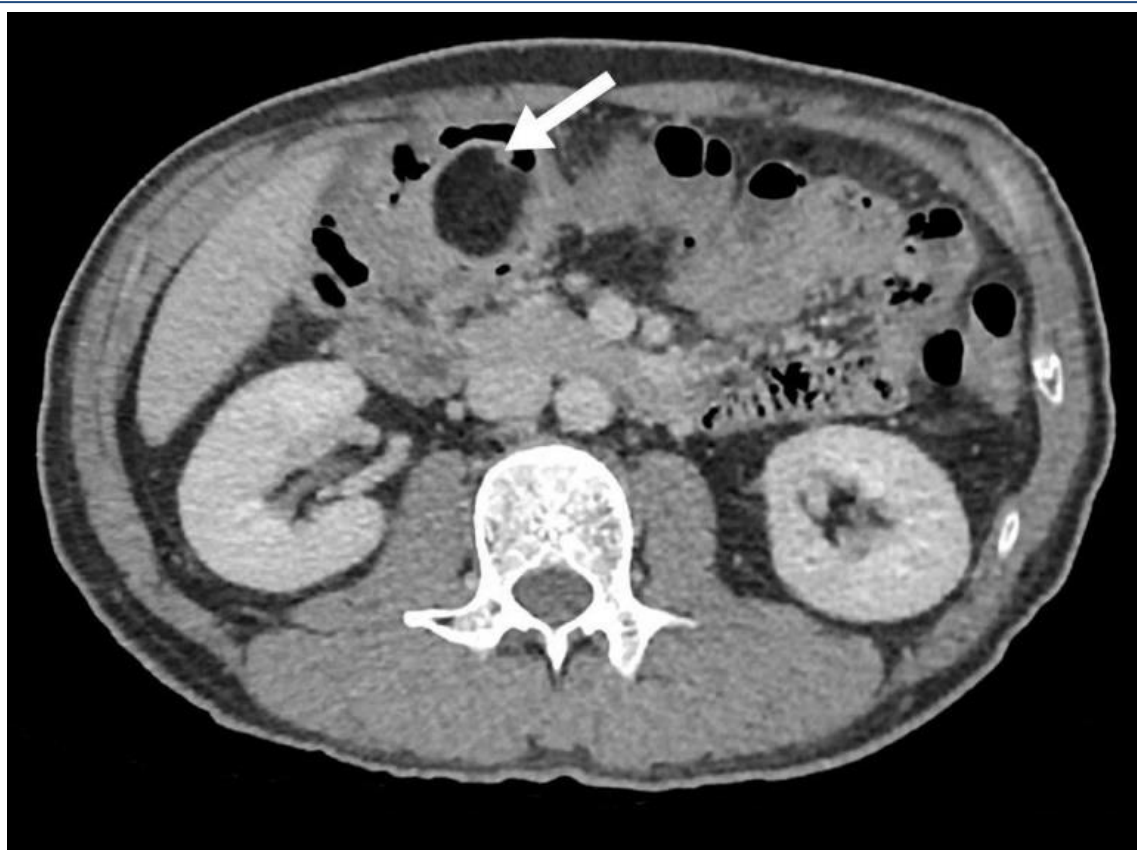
Repeat CT imaging findings.
